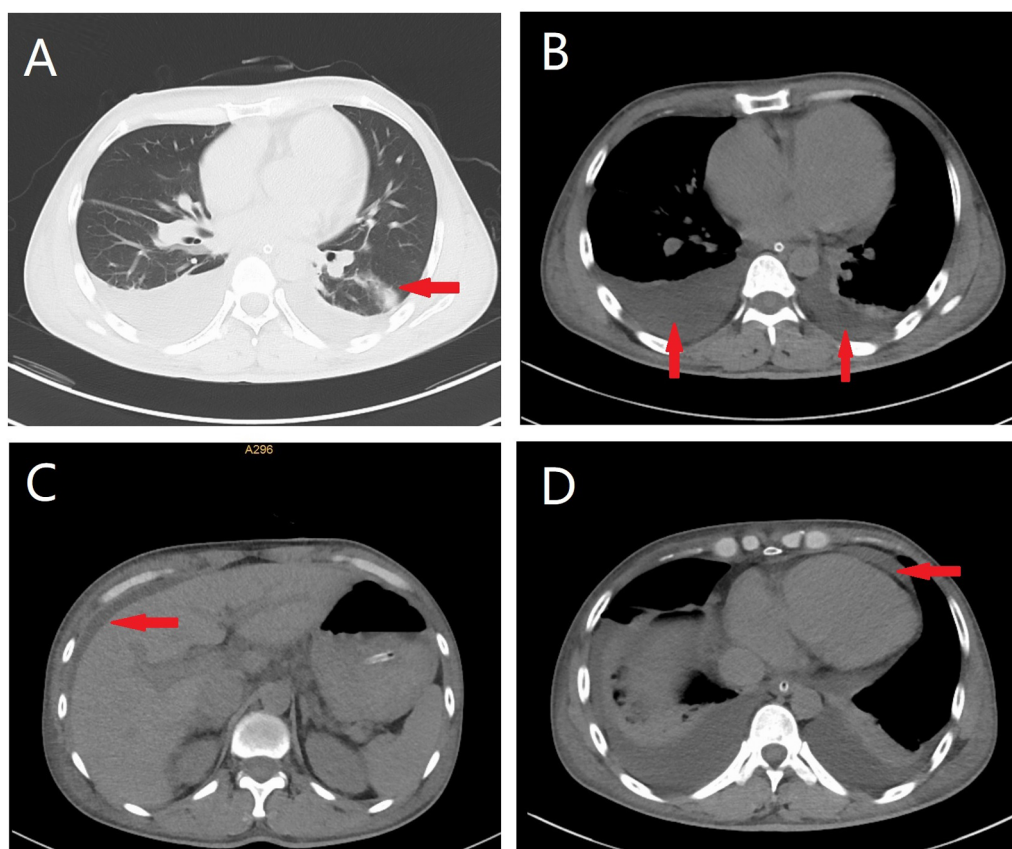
A Chest computed tomography revealed minimal pleural effusion (red arrow). B Bilateral thoracic computed tomography imaging demonstrated an accumulation of fluid in both hemithoraces, with the right side exhibiting greater involvement than the left (red arrows show the pleural fluid accumulation on both sides). C The liver periphery showed evidence of abdominal fluid accumulation (red arrow), accompanied by swelling of the gallbladder. D The heart demonstrated enlargement with concomitant accumulation of fluid within the pericardial sac (red arrow)
